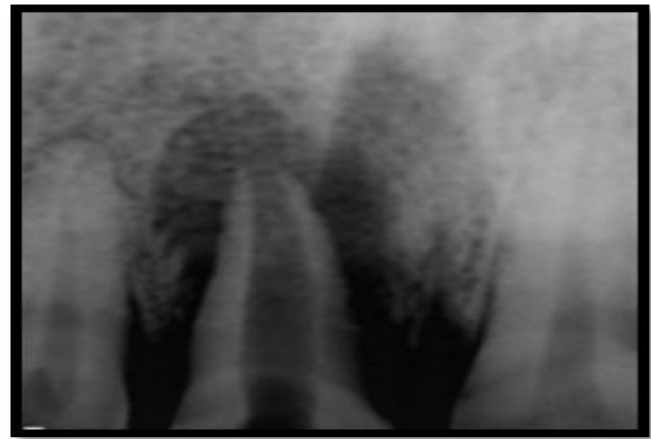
Pre-operative radiograph showing open apex
